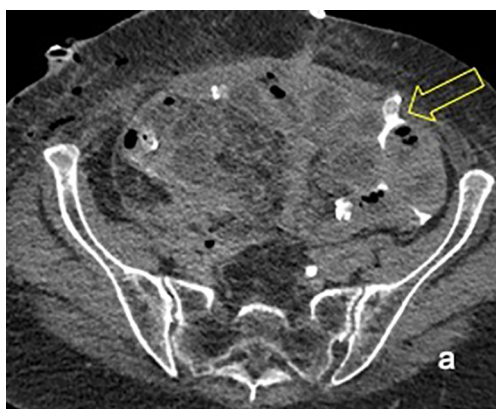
Uro-CT-scan imaging revealing the presence of ureteral fistula and uro-peritoneum in case #3. Excretory phase: spilled urine iodized around the drainage tube (empty arrow).
